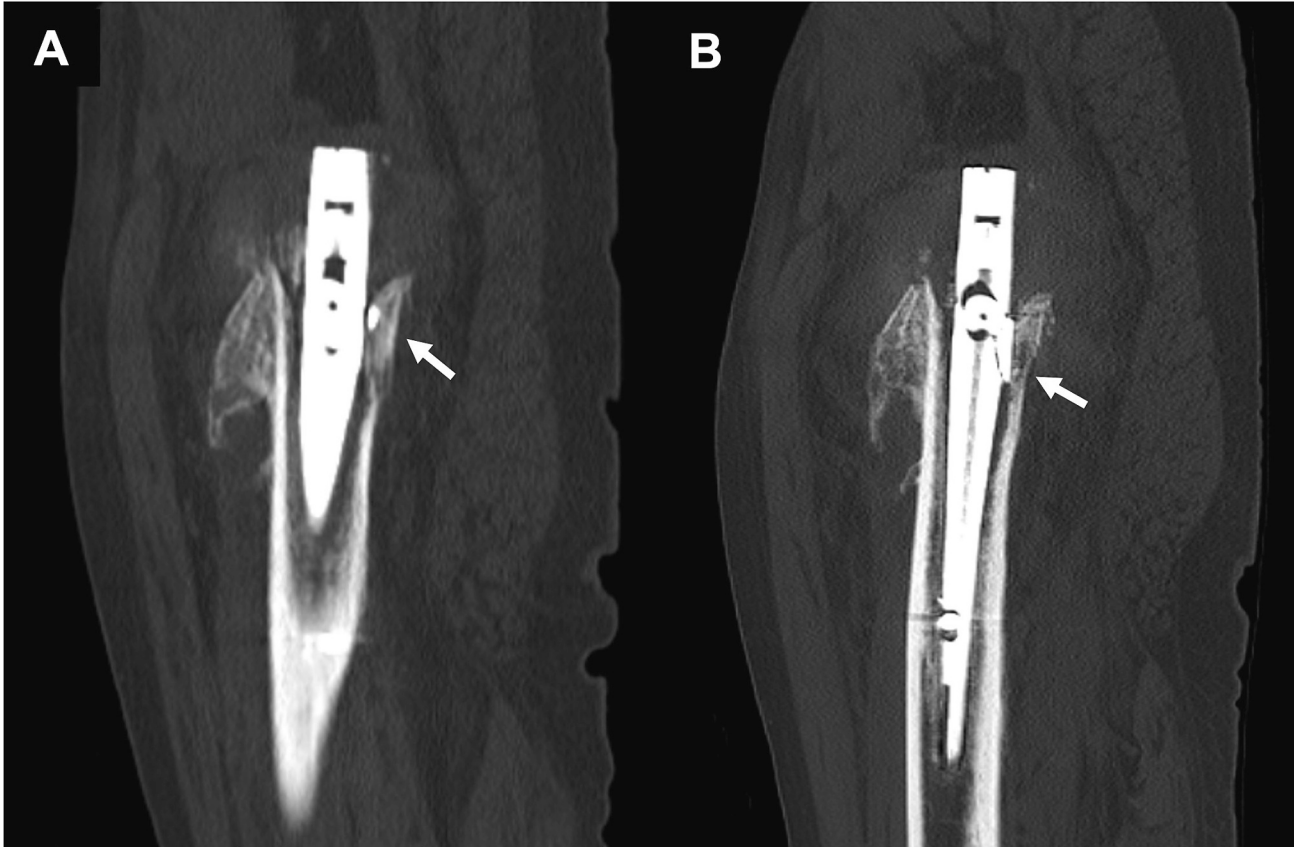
(A) Eight-month postoperative sagittal computed tomography scan showed partial damage at the lag screw hole (white arrow). (B) Nine-month postoperative sagittal computed tomography scan showed that the partial damage to the lag screw hole had worsened (white arrow).
